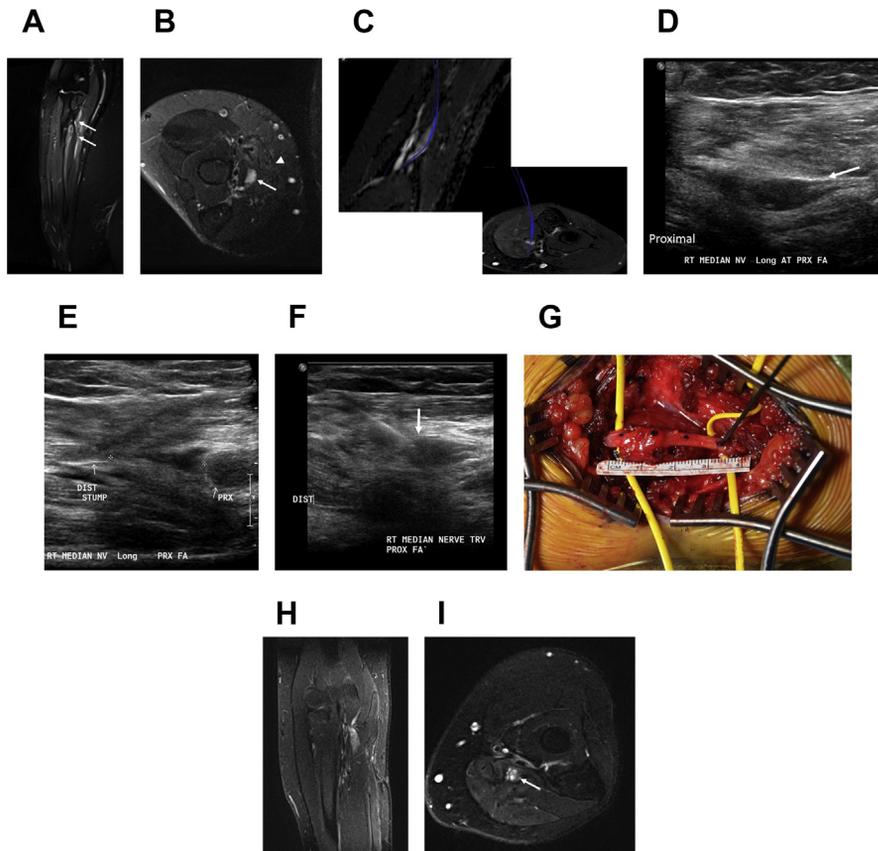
Median nerve neuroma-in-continuity in a 24-year-old woman after forearm laceration. (A) Coronal STIR image of an initial right forearm MRI reveals a 1.8-cm thinned segment of the nerve (*between arrows*). (B) Axial T2-weighted fat-suppressed image from the same study shows fusiform thickening of the median nerve just proximal to the thinned segment (*arrow*). There is mild flexor forearm muscle edema without atrophy (*arrowhead*). (C) Diffusion tractography images using thin-section coronal and axial STIR SPACE images to provide anatomic context show intact diffusion tracts along the course of the nerve, indicating at least partial fiber continuity. (D) Long-axis ultrasound of the median nerve at the site of prior laceration shows a 1.0-cm long hypoechoic fusiform segment of the nerve that represents the neuroma-in-continuity (*arrow*). (E) Just distal to the lesion, on the same study, there is an apparent 1.7-cm gap in the nerve with proximal and distal stumps labeled (*between calipers*). (F) Intraoperative long-axis ultrasound of the median nerve shows the long axis of a 25-gauge needle connected to a syringe containing methylene blue extending to the superficial surface of the neuroma-in-continuity (*arrow*). Methylene blue was injected at the surface of the lesion and along the needle path as it was slowly withdrawn to the skin surface. (G) Intraoperative surgical exploration of the forearm shows yellow ties proximal and distal to the abnormal segment of the nerve. There is fusiform thickening of the nerve proximally. (H) Repeat forearm MR neurography performed 6 months after neurolysis shows fusiform thickening of the nerve in the segment of the nerve in which there was an apparent gap, which was believed to present granulation tissue and fibrosis. The gap was much less conspicuous, suggesting healing. (I) Axial T2-weighted fat-suppressed image of the upper forearm shows persistent nerve fasciculation (*arrow*). The previously noted flexor muscle edema has resolved, however, consistent with the functional improvement the patient reported.
